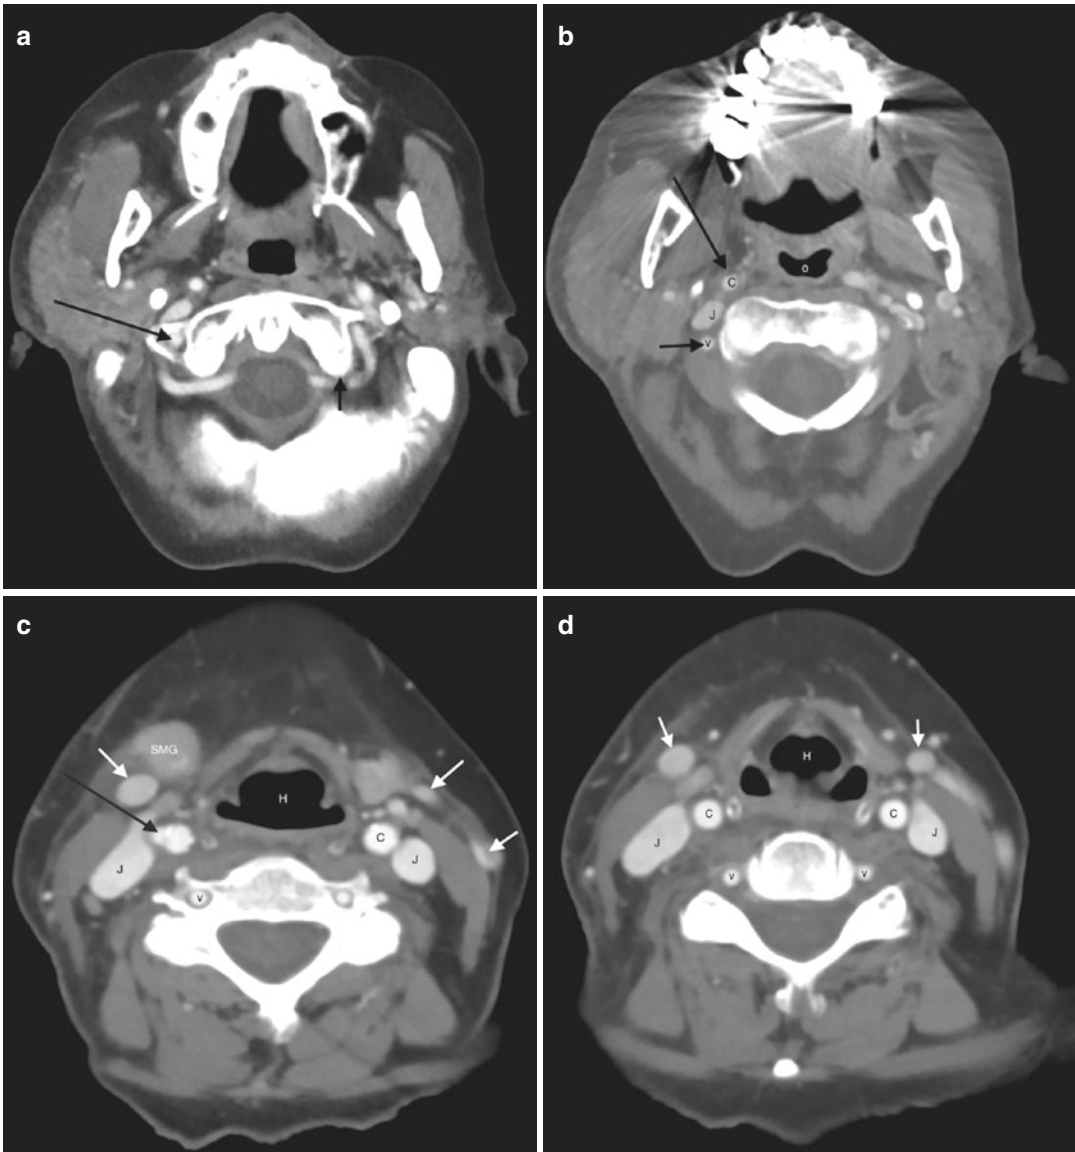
Axial contrast-enhanced CT image (a) at C1 level shows course of vertebral arteries as they emerge from the C1 transverse foramen (*large arrow*) to course posterior to the lateral mass (*small arrow*), along a groove on the superior surface of the C1 neural arch, and then enter the spinal canal. Axial contrast-enhanced CT image (b) at C2 level shows enhancing vascular structures adjacent to lateral aspect of C2 (internal carotid artery (*c*; *large arrow*), internal jugular vein (*J*) and vertebral artery (*V*; *small arrow*)). If this were a biopsy case, this vascular anatomy effectively forms a barrier to biopsy needle access from these directions. The oropharynx (*O*) forms the anterior relation of the C2 vertebral body. Axial
